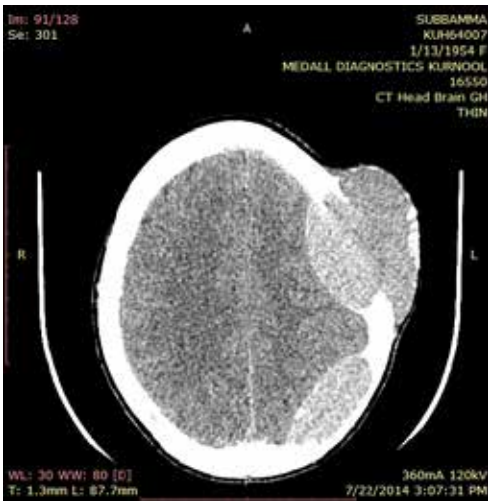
Computed tomography of brain showing other osteolytic lesions along with this large solitary, bone eroding lesion with mass effect over cerebrum
